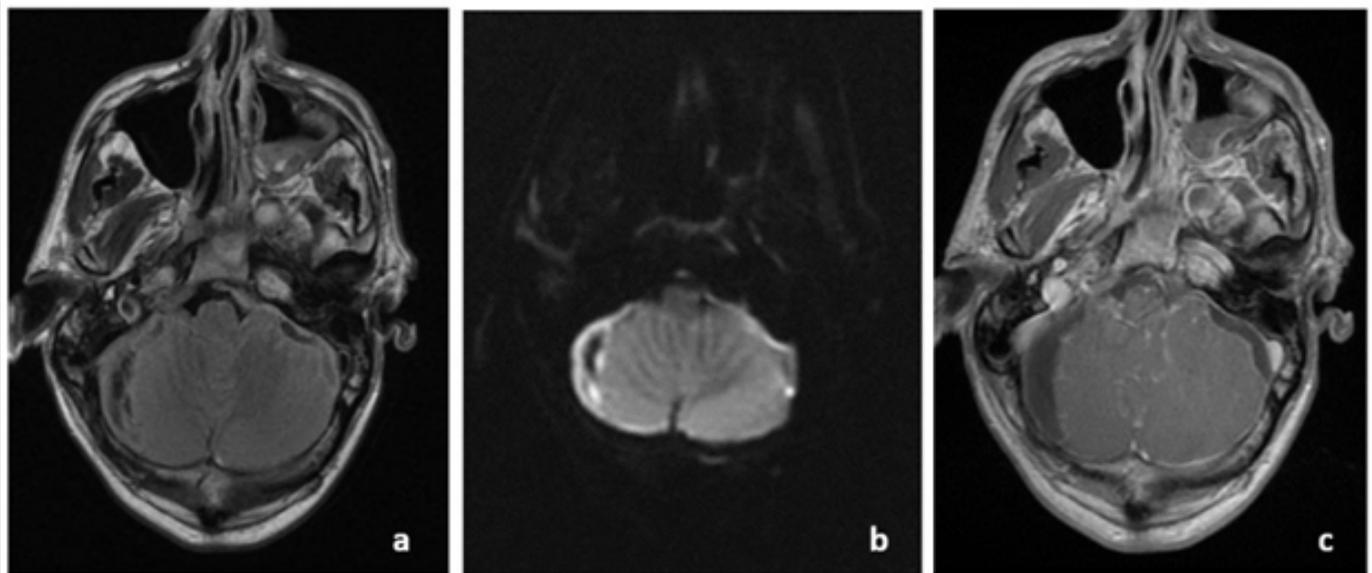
Subdural empyema at the posterior fossa on FLAIR (a), DWI (b) and T1 with gadolinium contrast (c) MRI (day 14 after admission)
